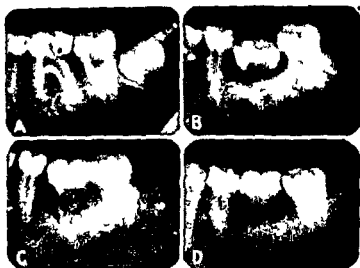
Radiographs of a 15 year old girl whose carious permanent first molar tooth was replaced by her own impacted third molar. A Before operation. B Three weeks after operation. C Seven months after operation. D Three and one half years after operation. (Dr Edward Weiner's case. Figures A-C reproduced from the *Transplantation Bulletin* by courtesy of the publishers and Dr Weiner. Figure D by courtesy of Dr Weiner.)
